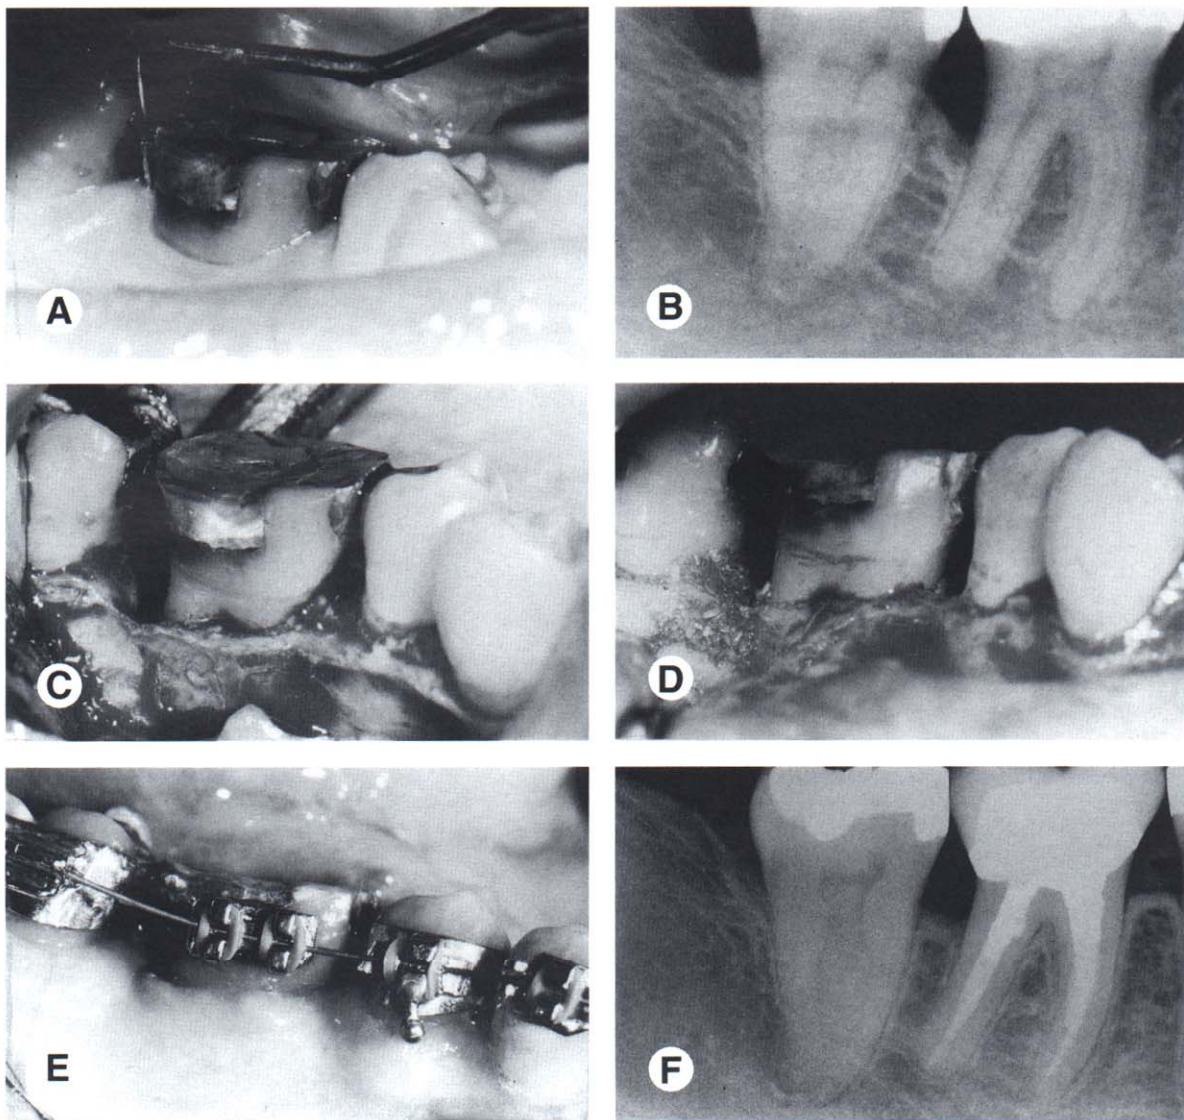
This patient had a significant periodontal pocket (A) distal to the mandibular right first molar. A periapical radiograph (B) confirmed the osseous defect. A flap was elevated (C) revealing a deep three-wall osseous defect. Freeze-dried bone (D) was placed in the defect. Six months after the bone graft, orthodontic treatment was initiated (E). The final periapical radiograph shows that the preorthodontic bone graft helped to regenerate bone and eliminate the defect distal to the molar (F).
